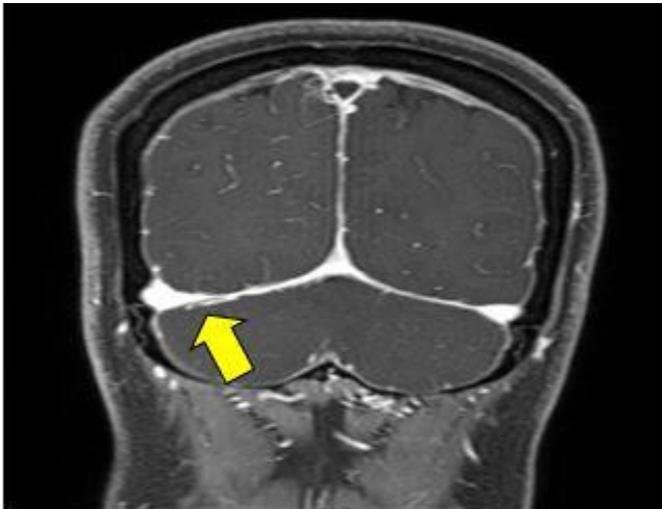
T1-weighted magnetic resonance image shows minute SDH in tentorium 3 weeks after the initial manifestations.
